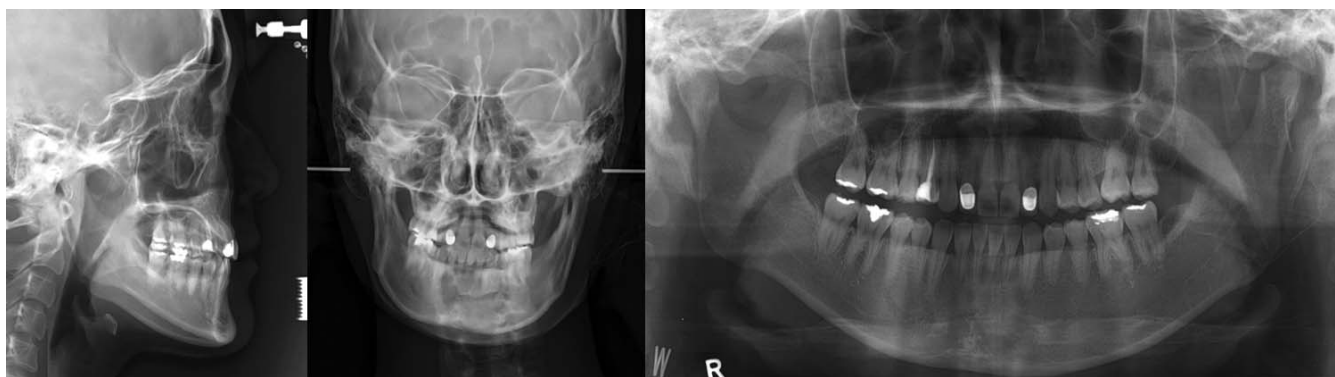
Lateral and posteroanterior cephalograms and panoramic radiograph taken 1 day after proportional condylectomy (age 29 years, 4 months).
